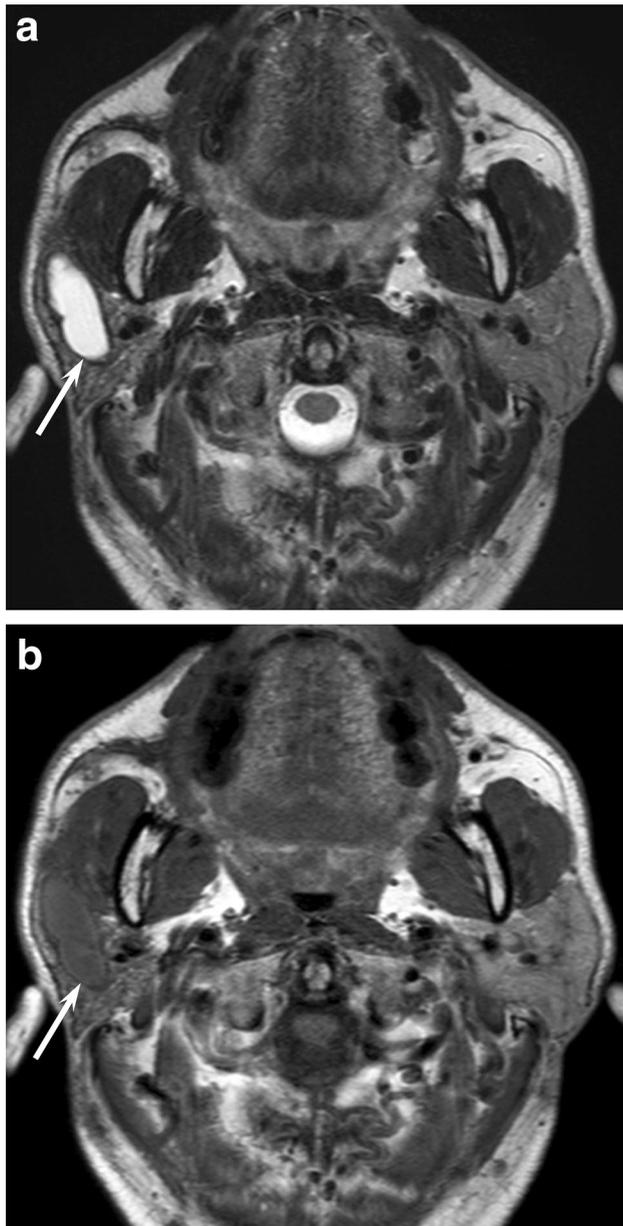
A 55-year-old man with sialodochitis fibrinosa. a T2-weighted image shows an elongated cystic lesion (arrow) in the right parotid gland. b T1-weighted image shows a slightly hyperintense cystic lesion (arrow) compared with the muscles
